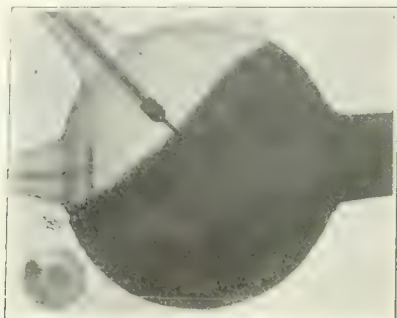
Radiograph of tube with anterior hemisphere covered with lead paint.
